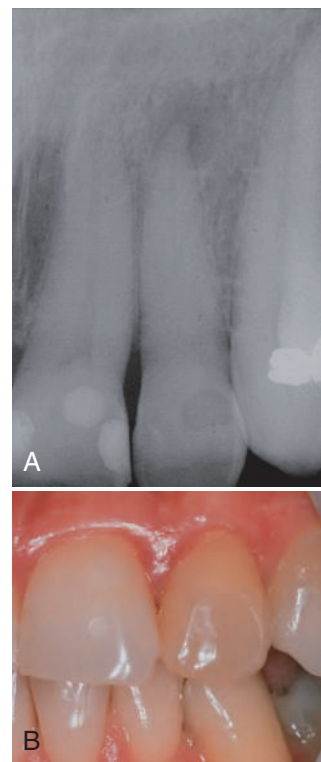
A, Pulp canal calcification after a luxation injury. Radiographic appearance of a calcified maxillary lateral incisor; note that despite calcification, it has now become necrotic and infected, evident by the periapical lesion. B, The typical yellow appearance of the tooth caused by thickened dentin in the pulp chamber.
